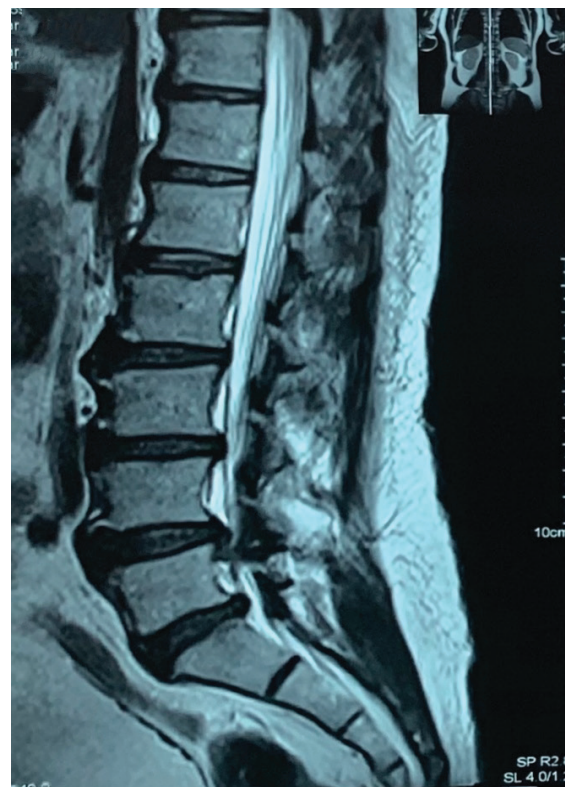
Sagittal T2-weighted MRI image of the lumbar spine showing downward herniated disc at L4/5 on the right side
